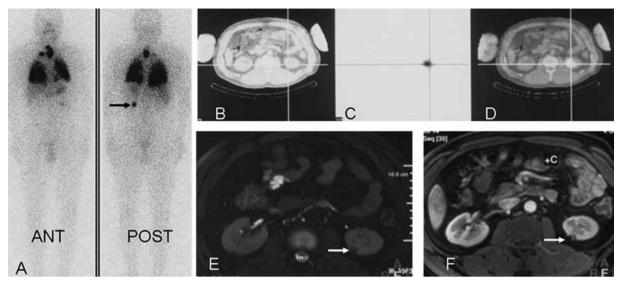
A 40-year-old male patient who presented mediastinal lymph node and pulmonary metastases from papillary thyroid cancer was treated with ¹³¹I for postsurgical thyroid remnants and metastases. An unexpected lesion with ¹³¹I uptake in the left abdomen, mediastinal lymph node, and lungs (suggesting metastasis) was observed on a ¹³¹I-WBS 5 days after an oral therapeutic dose of ¹³¹I (A: arrow). To localize this unexpected lesion of ¹³¹I uptake, a subsequent low-dose ¹³¹I-SPECT/CT scan was performed using a GE Hawkeye Millennium. Fusion images showed that the lesion was located in the left kidney (B-D: crossing line). Further examination with MRI revealed a solitary metastatic lesion with a diameter of 8 mm in the upper pole of the left kidney (E-F: arrow).
